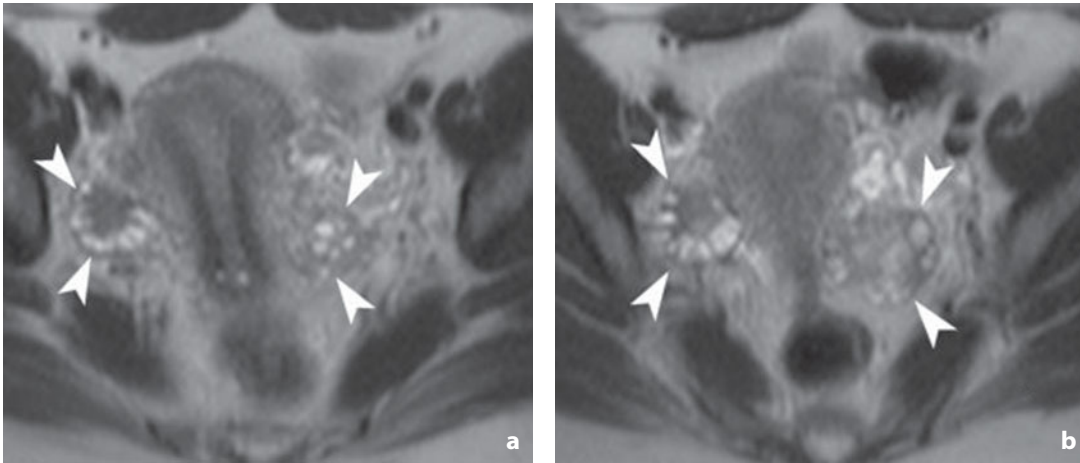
Magnetic resonance. Polycystic ovary. Axial T2-weighted images. Multiple follicles are identifiable on the surface of the ovaries (*arrowheads*). The stroma in the central portion of the right ovary is more hypointense than normal
